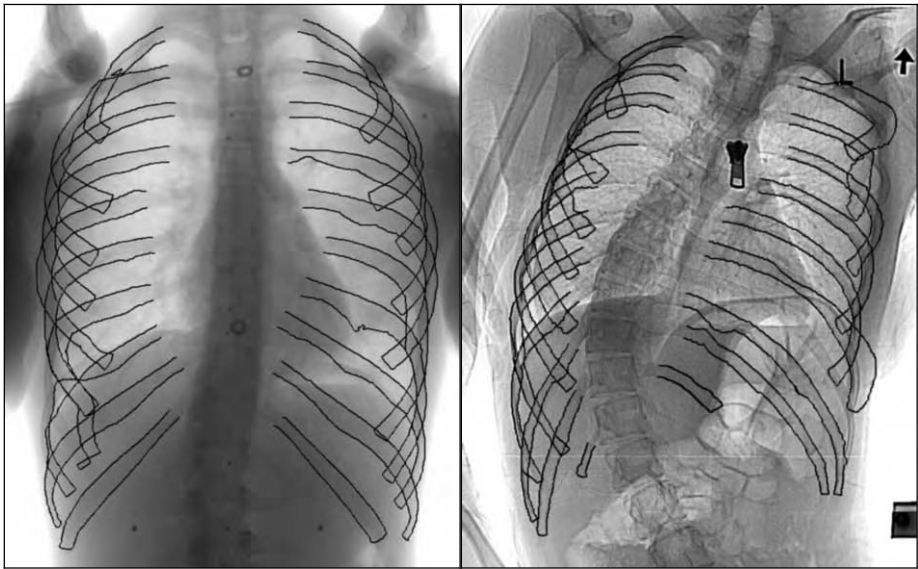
Detection results. Radiograph #1.
